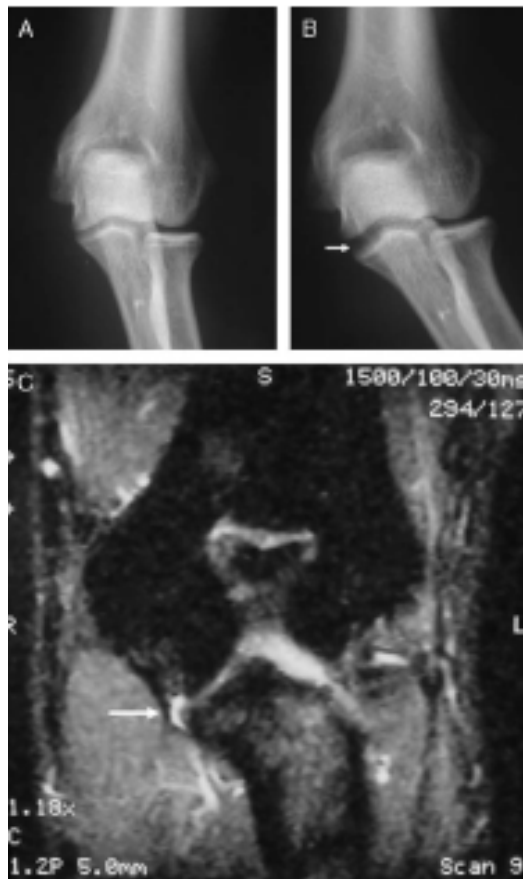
Imaging studies. (A) Plain anteroposterior radiograph of nonstressed elbow. (B) Stress anteroposterior view of the same elbow. Note the increase in space along the medial ulnohumeral joint line (arrow). (C) MRI depicting the capsular “T” sign pathognomonic of a partial UCL tear (arrow). (Nassab, 2006)
